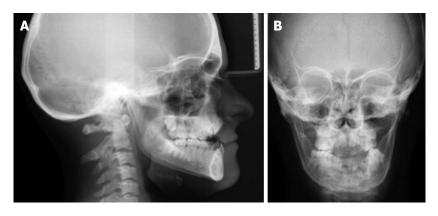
Sephalometric (A) and posterio-anterior radiographies (B) of the patient before orthodontic treatment.
